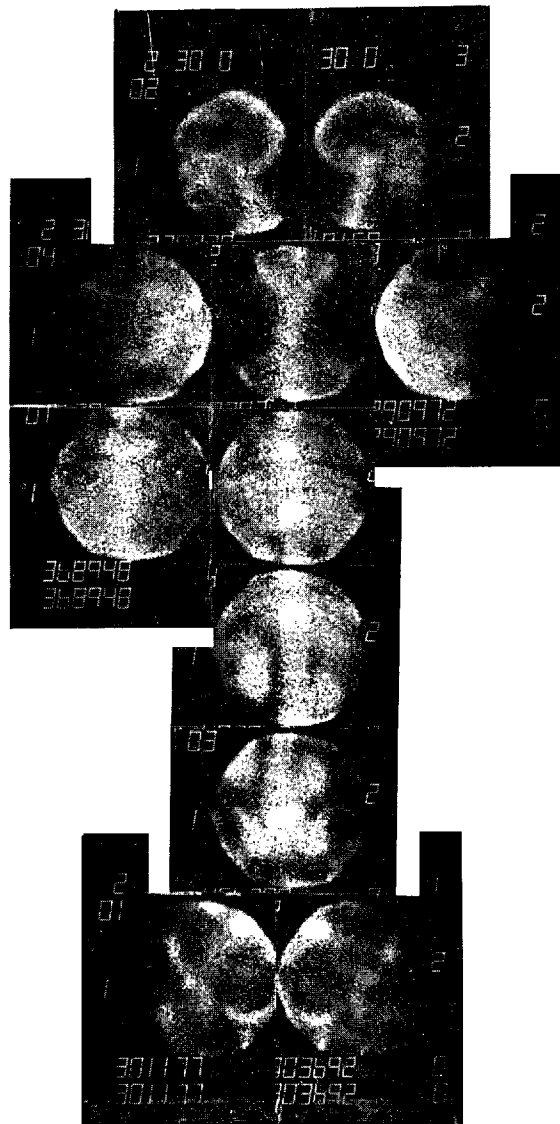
Patient with carcinoma of the breast. Metastases are clearly seen in the dorsal and lumbar spine at a time when the skeletal X-ray survey was normal. Multiple views obtained with a gamma camera.
